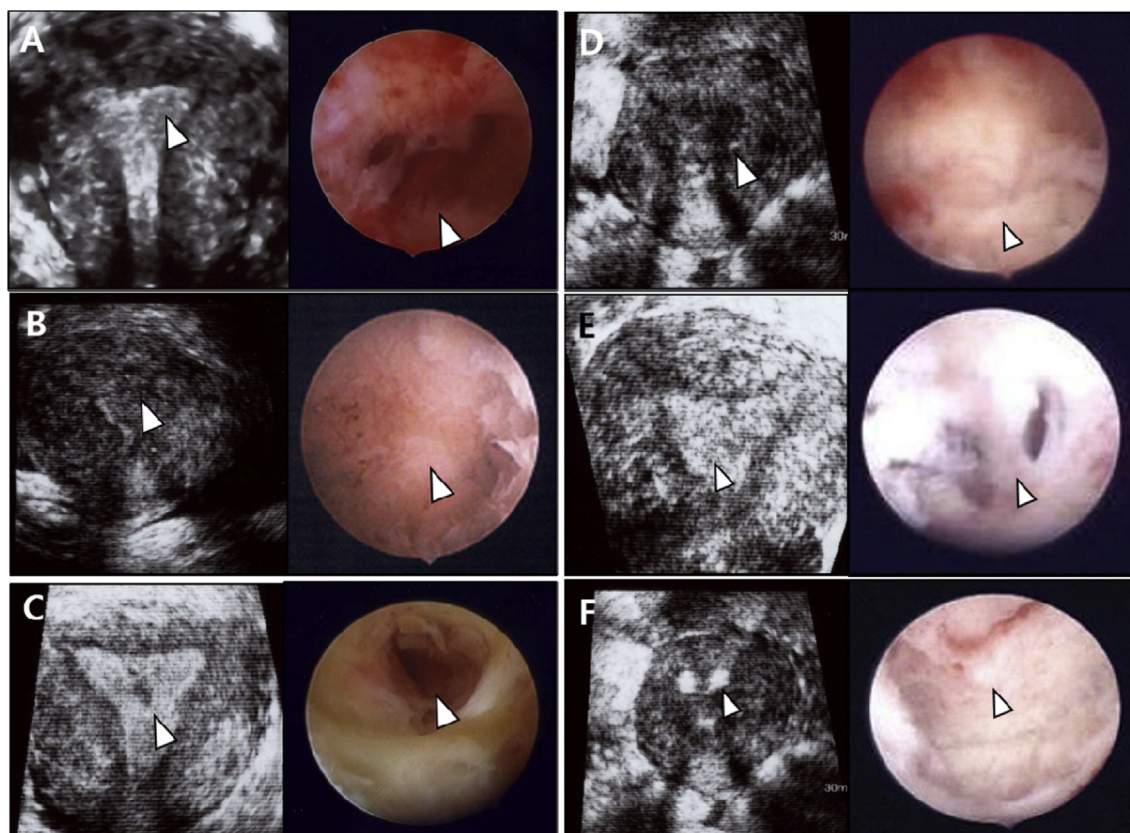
The classification of endometrial findings using three-dimensional ultrasound and suggesting intrauterine adhesion matched hysteroscopic findings: (A) marginal irregularity in sagittal plane, (B) thinning, (C) defect, (D) obliteration, (E) fibrosis, and (F) calcification.
